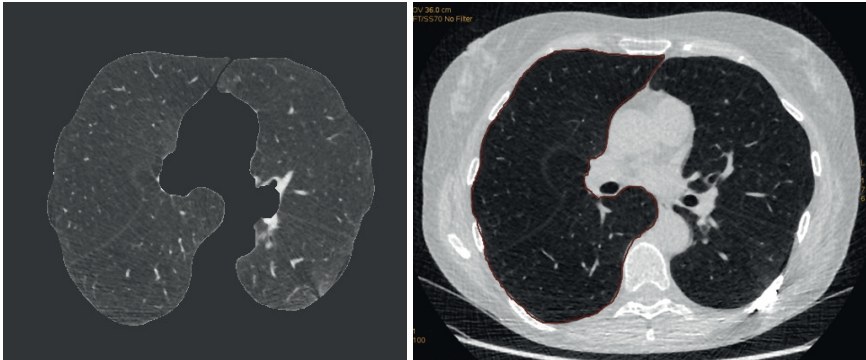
Automatic CT-lung volume estimation (left) and manual CT-lung volume estimation (right). Reproduced with permission from Caragounis et al., 2019. ¹¹⁰
